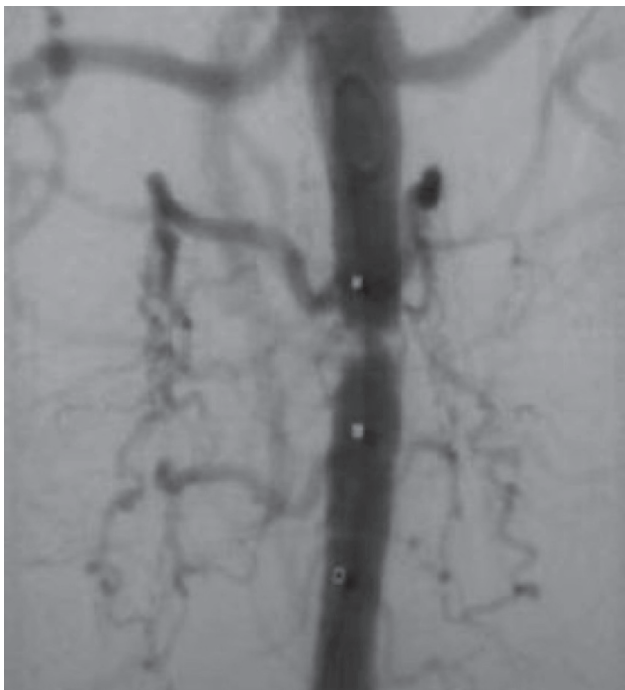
Computed tomography angiography (CTA) of the abdominal aorta and common iliac arteries.
